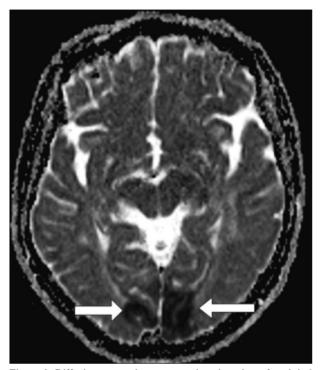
Diffusion magnetic resonance imaging view of occipital lobe infarct (Arrows)
